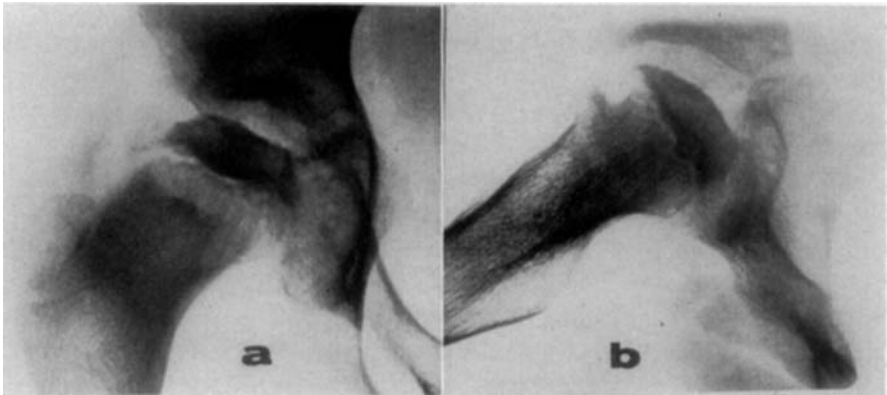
Case 54, boy aged 11 fell ill with fever and hip pain. Three months later, contracture and limitation of movement in the right hip. Radiographs at this time, *a*: frontal — and *b*: lateral view. Marked condensation and moderate flattening of the femoral epiphysis and a large step-shaped defect in the ventral margin of the metaphysis.
